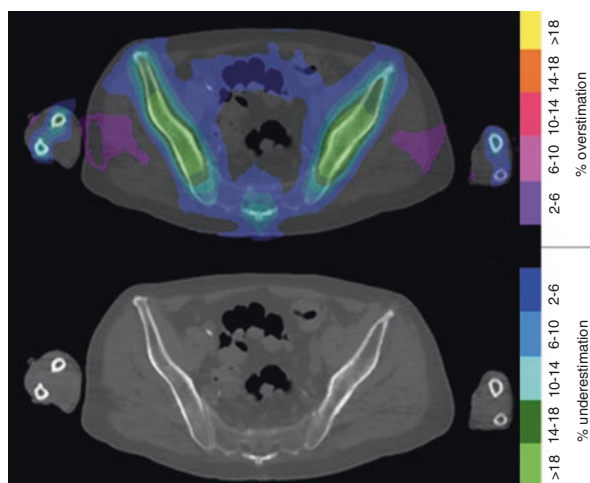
Relative difference between PET images reconstructed with and without considering bony structures on CTAC attenuation map with the corresponding axial CT image
